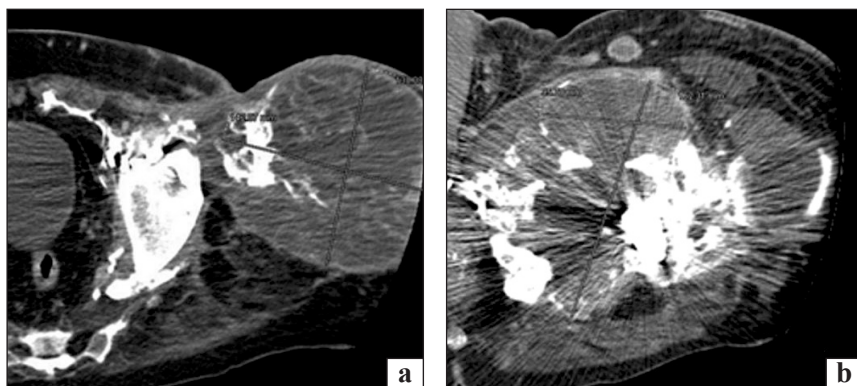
Multi CT examination showing two voluminous expansive masses, with a high degree of vascularization, at the root of the left thigh (a, b)
